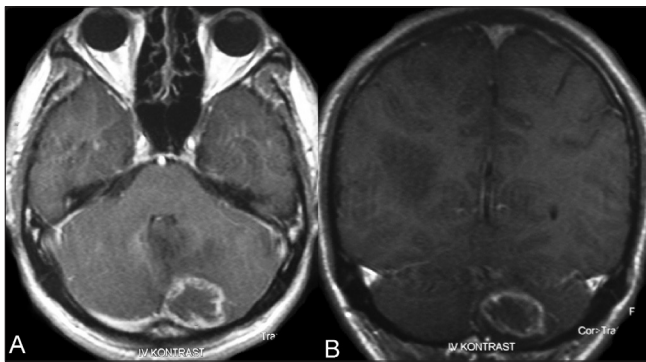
Gadolinium enhanced T1-weighted axial (A) and coronal (B) MR images demonstrate a left cerebellar lesion with peripheral enhancement.
